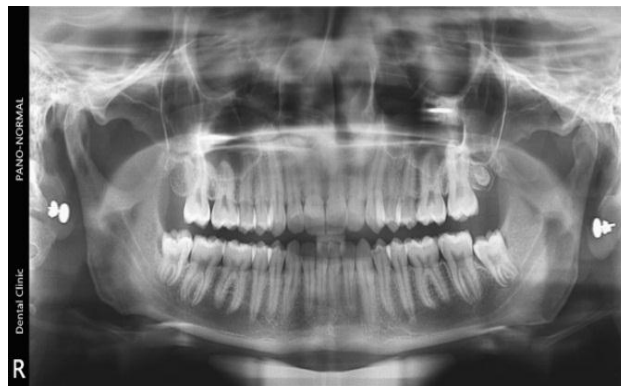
Orthopantomogram of patient
